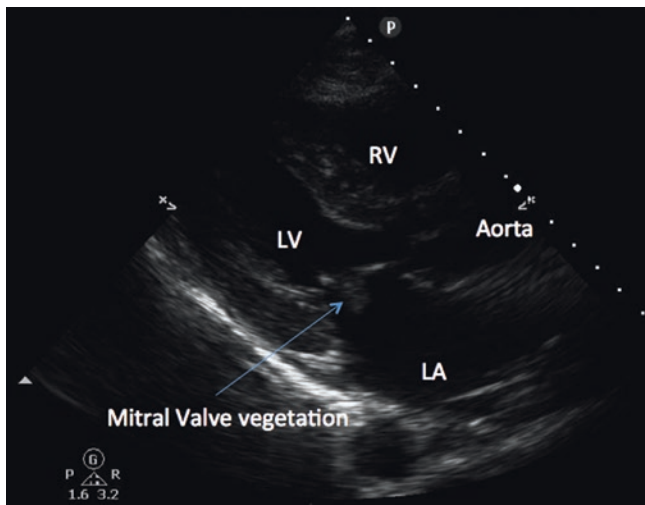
Cardiac ultrasound in a patient with fever and pulmonary edema. Point-of-care echocardiography shows mobile mitral valve vegetation in a middle-aged male admitted for fever, dyspnea, and pulmonary edema. Severe mitral regurgitation was also seen by color Doppler (not shown). A vegetation is defined as a discrete echodensity with independent mobility typically attached to the valve leaflets. Transthoracic echocardiography has a limited sensitivity for detection of vegetations and should be followed by transesophageal echocardiography in patients with high suspicion for endocarditis. In patients with established endocarditis, transesophageal echocardiogram can delineate the extent of involvement and detect complications (such as valve perforation, abscess formation, etc.). See also Video 37.9
